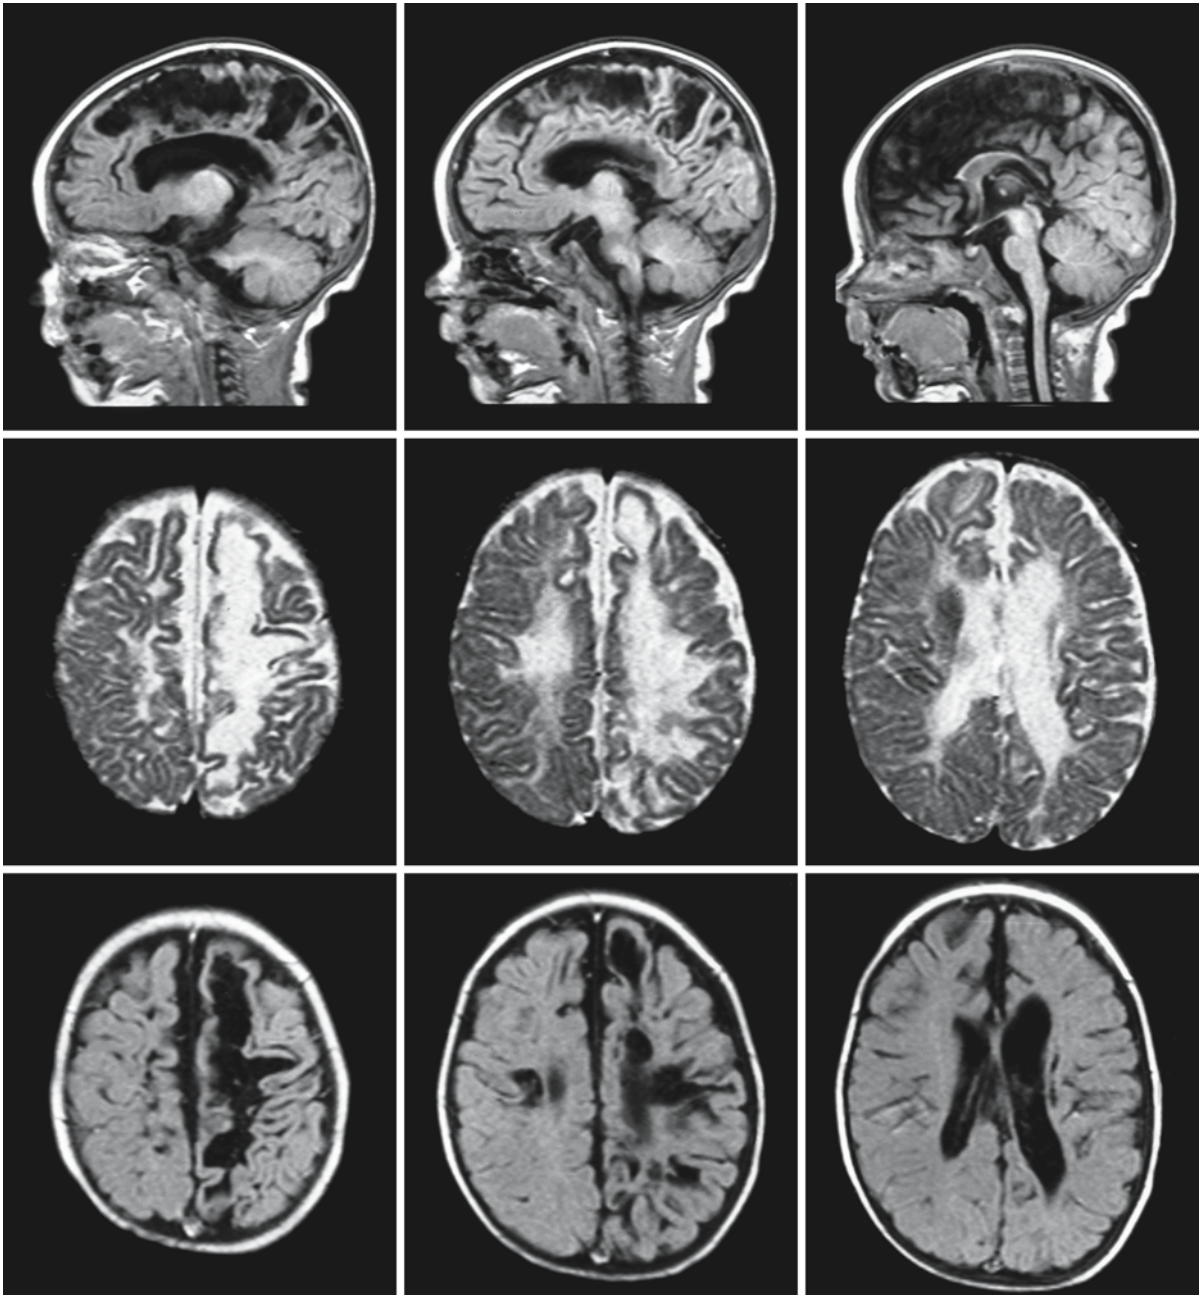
Follow-up MRI of the girl shown in Fig. 56.1. She is now 5 months old. There is a serious cystic degeneration of the deep and subcortical cerebral white matter, more prominently on the left than on the right. The overlying cortex is also
